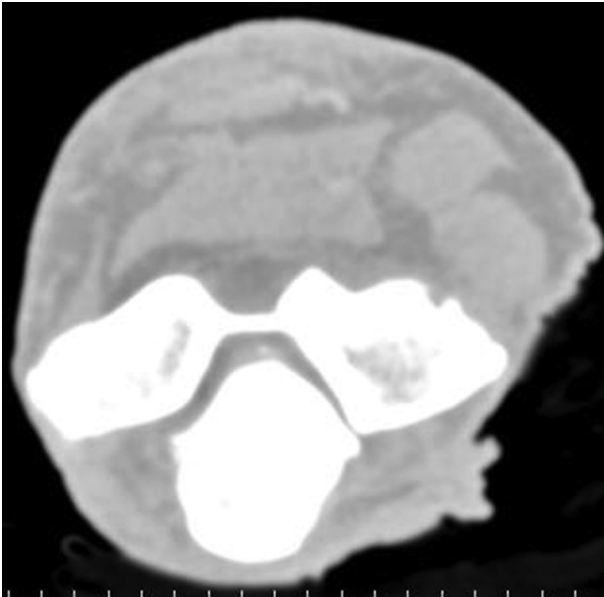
Axial CT cut of the Ulnohumeral joint with the lung viewing window. No intra-articular air is noted. *CT*, computed tomography.
